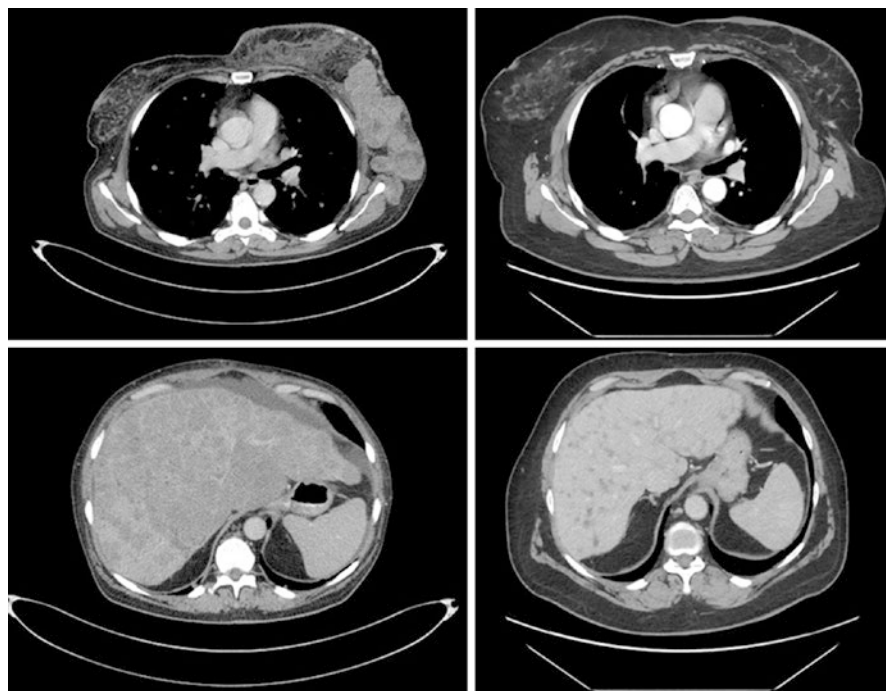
Computed tomography findings before (left) and after 6 months (right) of treatment with dabrafenib and trametinib in a patient with metastatic melanoma
